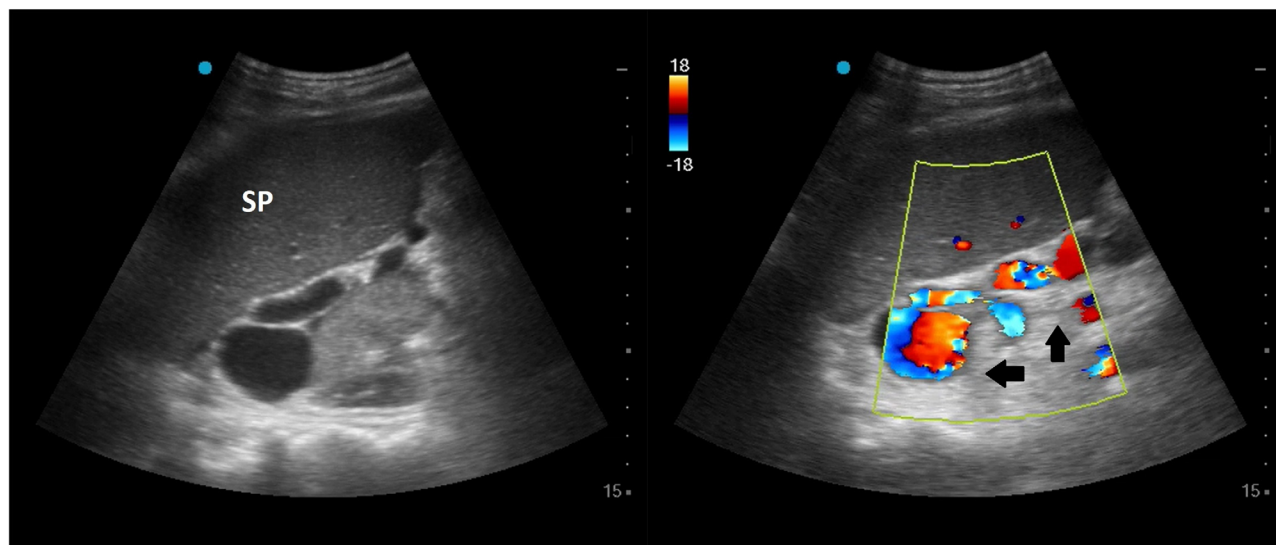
Ultrasonography performed in a coronal view at left flank near the splenorenal level showed clusters of dilated anechoic cystic structures along an enlarged spleen (left panel). Color doppler showed vascular flow signals within the anechoic structures between the spleen and left kidney (right panel, arrows). SP, spleen
